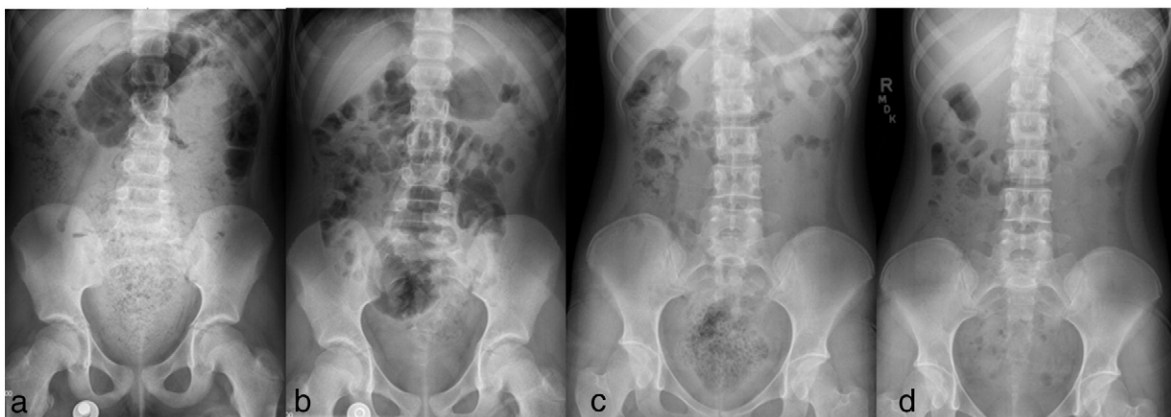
Abdominal radiographs during a bowel management week showing: a) fecal impaction, b) successful clean out with enemas, c) abdominal radiograph on beginning of the week showing stool in the rectum, d) abdominal radiograph in the end of the week on 60 mg of senna.
